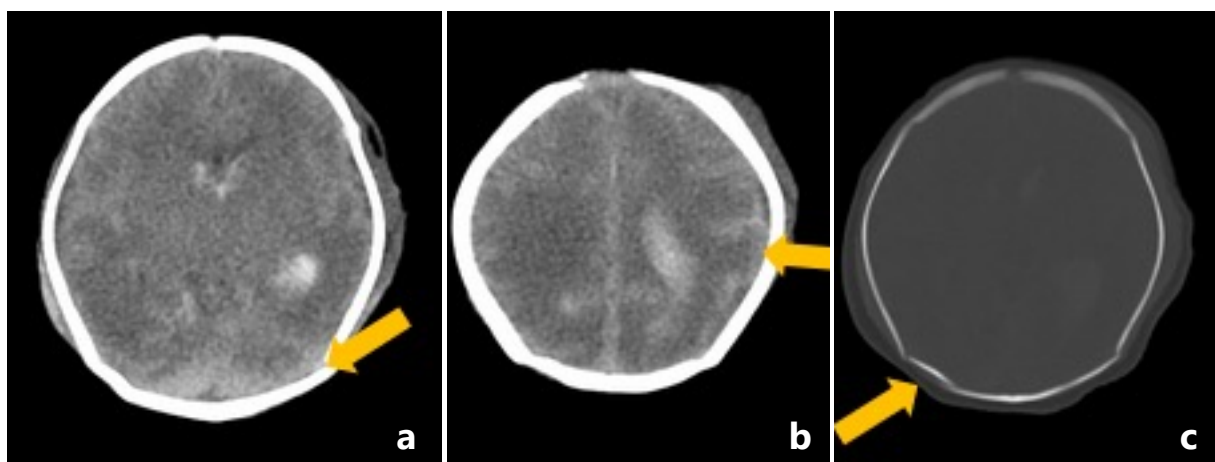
Non-enhanced CT brain of a premature infant born at 32 weeks of gestation born via forceps-assisted delivery. (a) Subdural haematoma is seen along the tentorium (arrow), (b, c) demonstrate grade III intraventricular haemorrhage and subarachnoid haemorrhage (arrow), with marked cerebral oedema and sulcal effacement. (c) On the bone window, there is a mildly depressed fracture involving the occipital bone (arrow).
